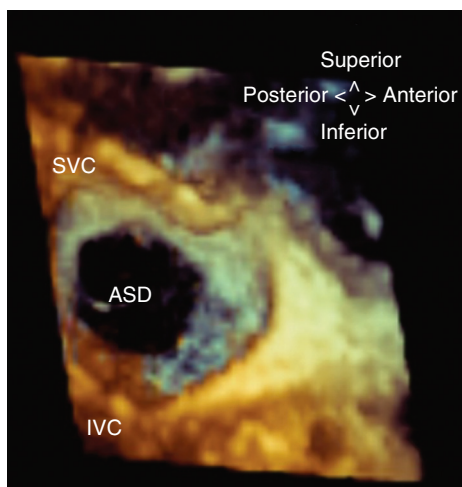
Three-dimensional secundum ASD. This real-time three-dimensional echocardiographic image obtained by TEE demonstrates the rims of a large secundum ASD, as seen from the right atrium. IVC = inferior vena cava, SVC = superior vena cava.
